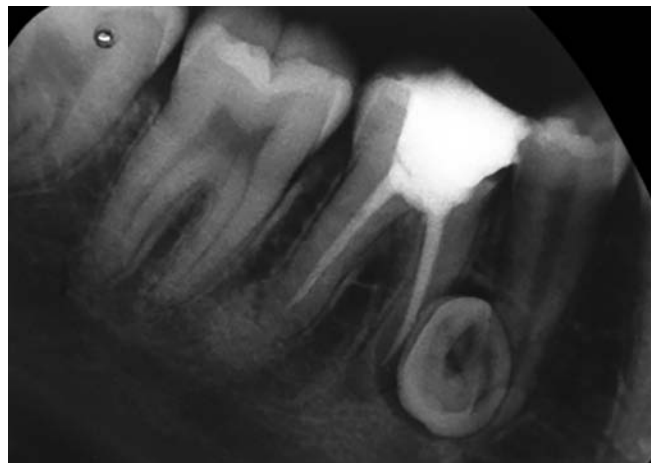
X-ray showing root canal filling with lower right mandibular first molar
